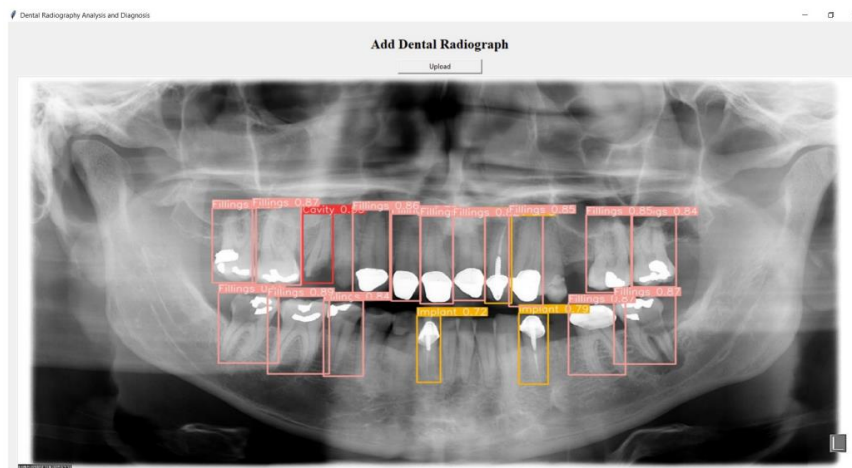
GUI of Dental Radiography Analysis and Diagnosis
